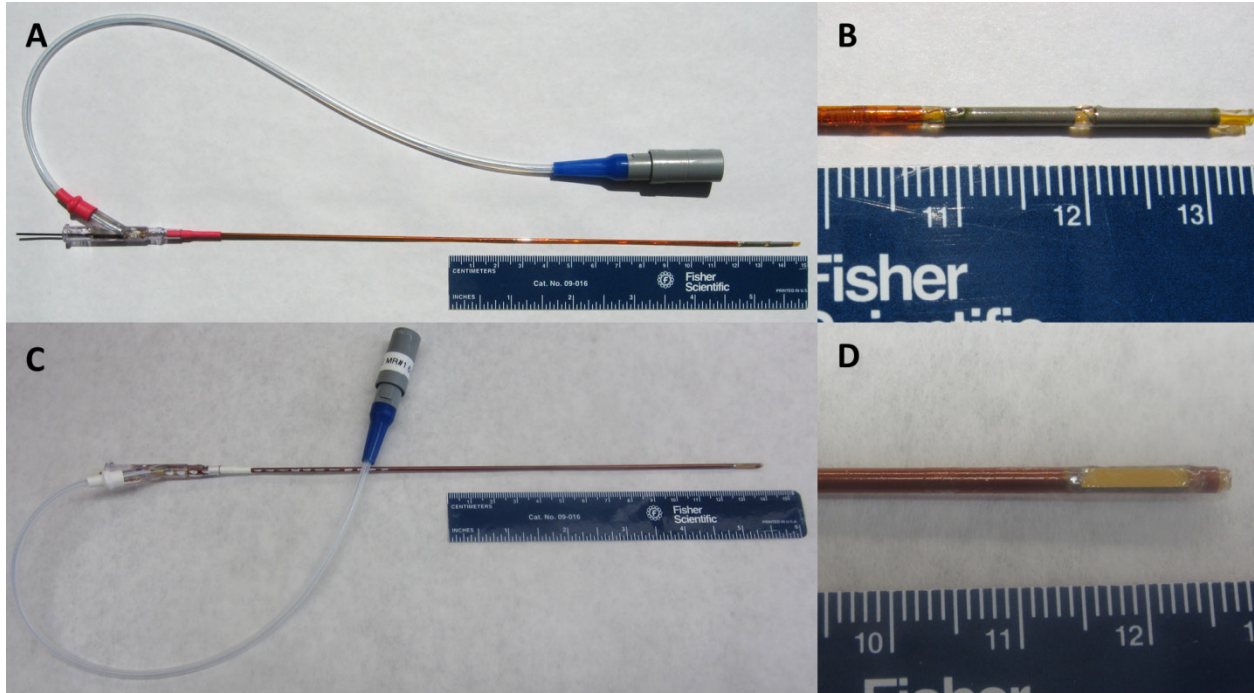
Examples of interstitial ultrasound applicators with tubular (A-B) and planar (C-D) transducers. The full applicators are shown in A and C, and the transducers at the tips are shown in B (gray) and D (gold).
